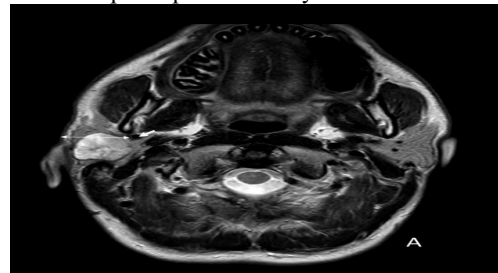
Axial T2-weighted image demonstrating the measurement of the distance between the retromandibular vein (RMV) and the skin on the tumor side in the right parotid gland (A) and in the normal contralateral parotid gland (B).
